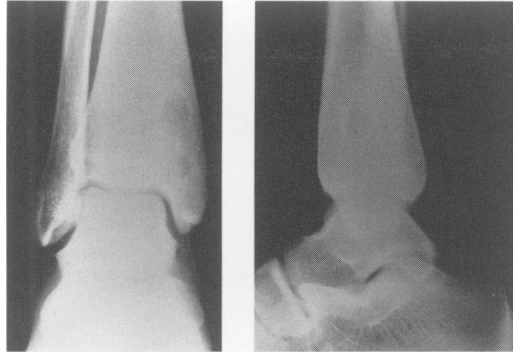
X-ray of right ankle
